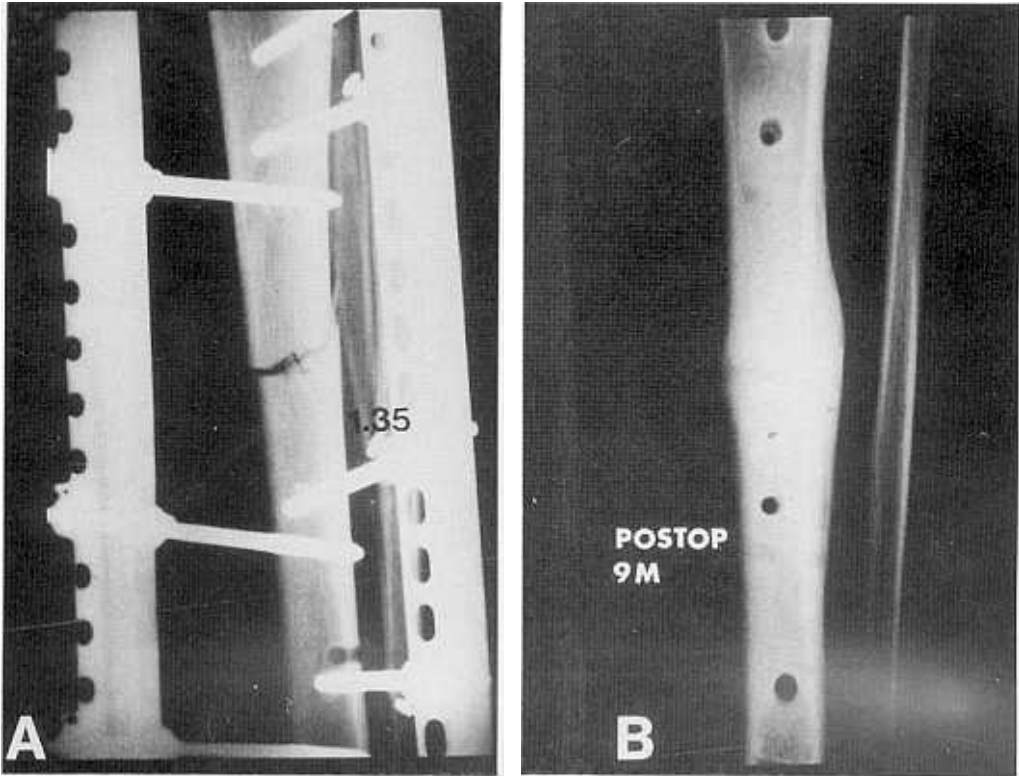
A. Postoperative roentgenogram of a 27-year-old man who sustained a type 2 open transverse tibial fracture. Tibia was reduced and fixed with a Judet external fixator in biocompressive mode. The gap in medial cortex was 1.35 mm. B. After 9 months postoperatively, the fracture was healed with matured periosteal callus.
